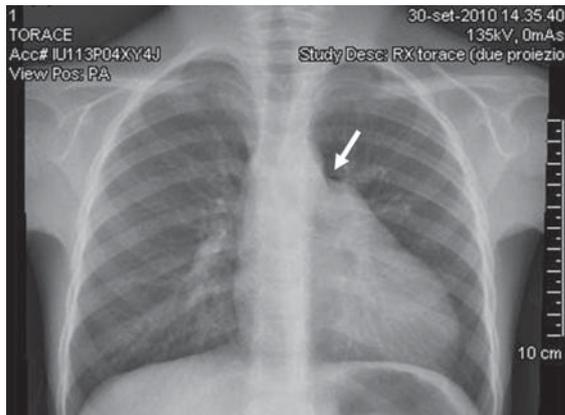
Chest X-ray showing the prominence of the left second cardiac arch, with an incision (arrow) between the first and second arch, due to the pericardial defect.
